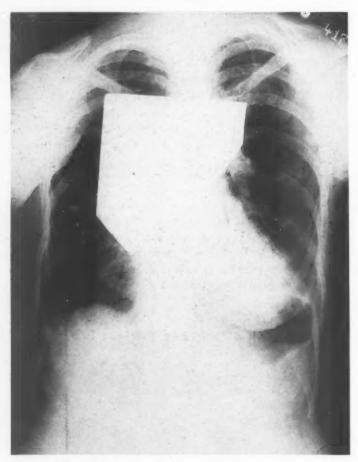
Roentgenogram made fourteen weeks following operation showing tantalum plate in position.
